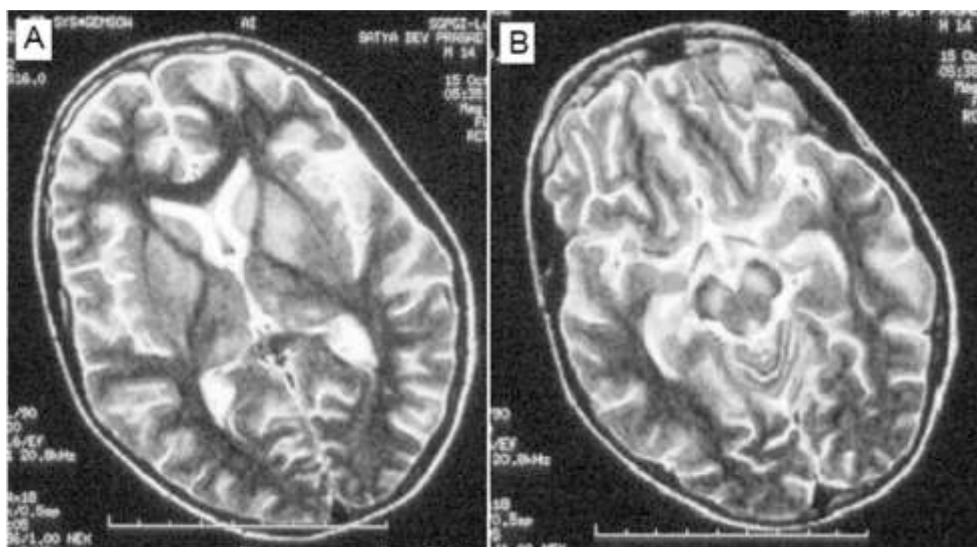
Cranial MRI, T2 sequence axial section showing hyper intensity in thalamus and basal ganglia (A) and in midbrain (B)
